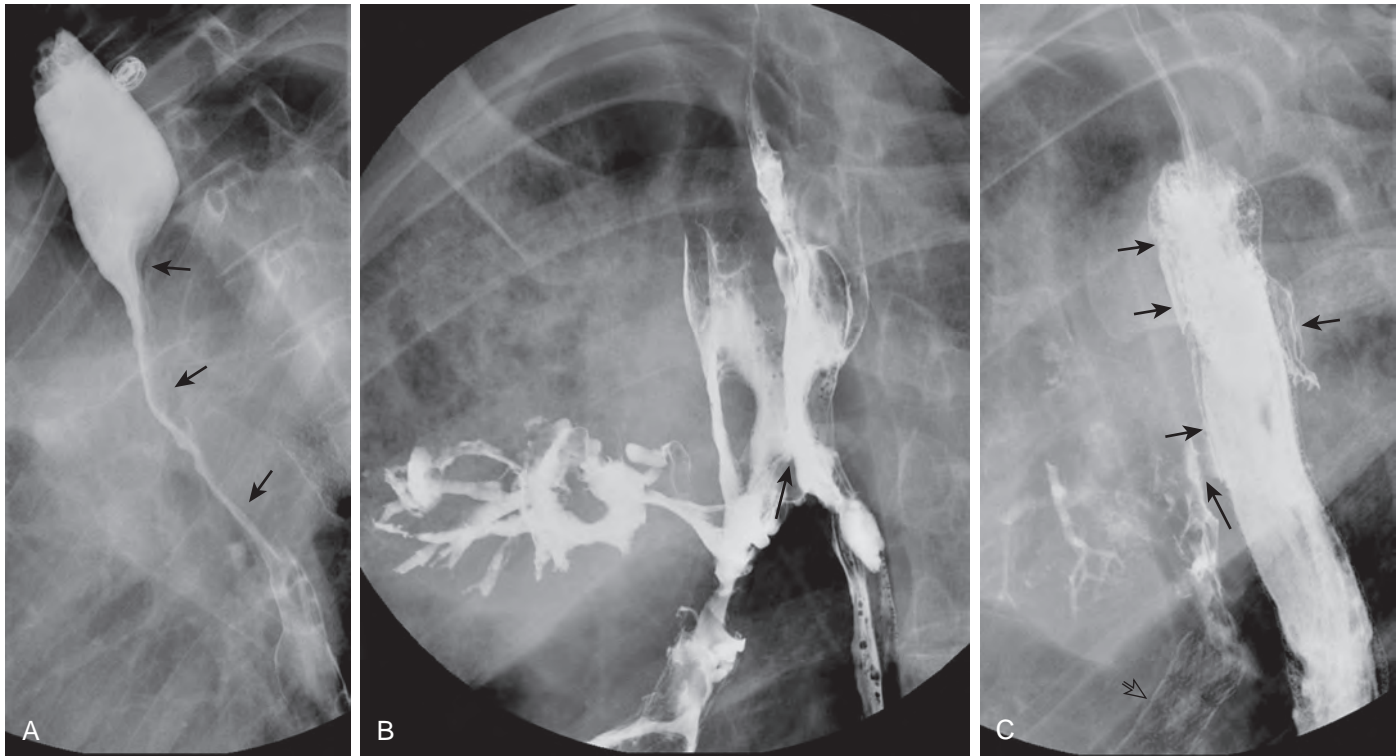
Stent placement for squamous cell carcinoma of the right lung invading the esophagus. A. Spot radiograph of the right upper mediastinum with the patient in a right posterior oblique position shows a 10-cm long, broad-based extrinsic mass impression on the posterior wall of the esophagus (arrows). B. Spot radiograph obtained 3 months later, after radiation therapy, shows less extrinsic mass impression. However, a fistula (arrow) from tumor at the carina invading the esophagus has now formed. Bronchi and the trachea are filled with barium. Presumptively, necrosis of the tumor after radiation therapy has contributed to the fistula formation. A stent is also present in the right mainstem bronchus. C. Spot radiograph obtained after esophageal stent placement shows barium going through the uncovered portion of the stent to surround the stent (short arrows). This barium eventually goes into the tracheoesophageal fistula (long arrow). The stent in the right mainstem bronchus is identified (open arrow).
